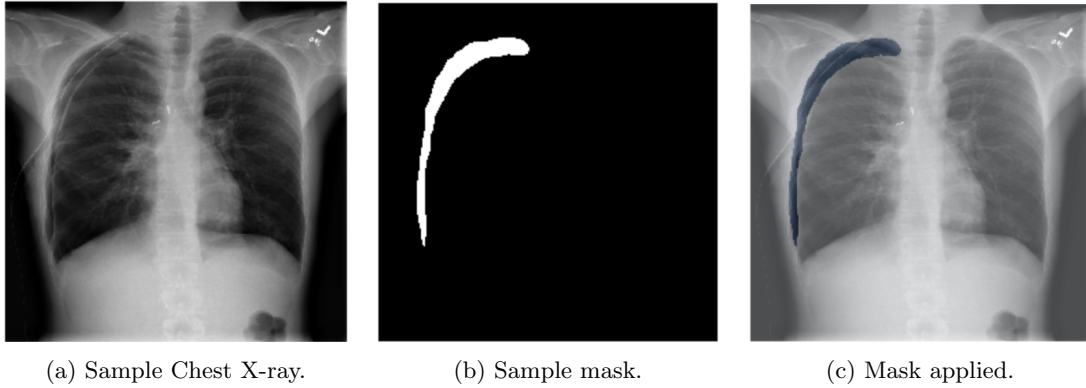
Sample chest X-ray image along with its mask and mask applied.
